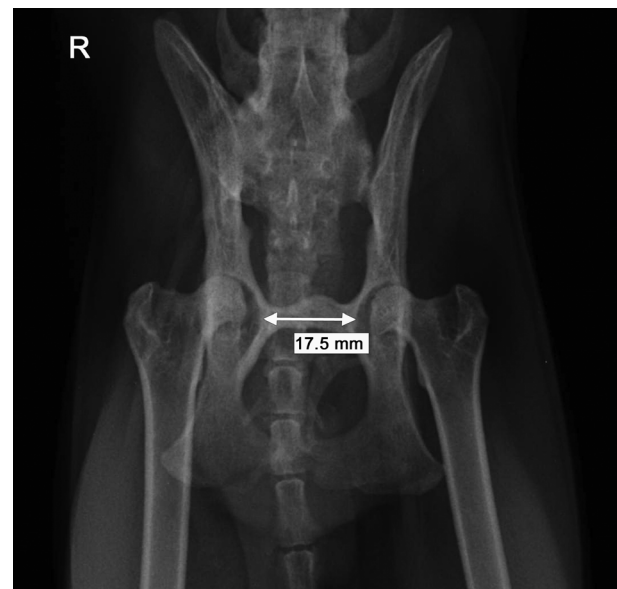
Ventrodorsal pelvic radiograph taken at the 18-month follow-up
